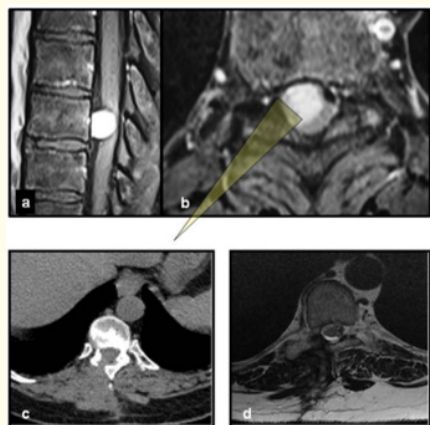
Sagittal (a) and axial (b) contrast enhanced T1 weighted MRI images demonstrate anterolateral located meningioma with contrast enhancement and spinal cord compression. The posterolateral triangle represents the possible safe trajectory for surgical exposure of the tumor. Postoperative axial computed tomography section (c) and axial T2 weighted MR image (d) show the hemilaminectomy defect and totally resected tumor with decompression of the spinal cord, respectively.
